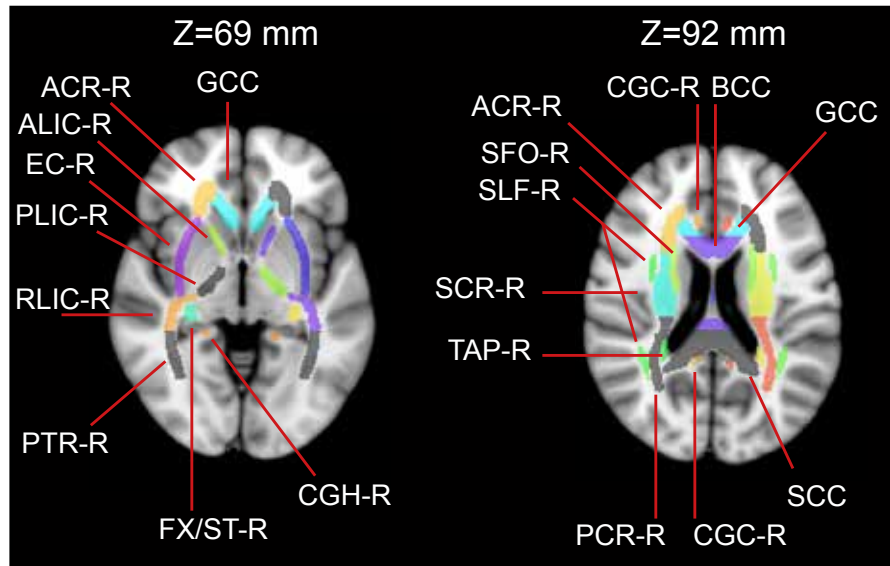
Two axial views, at $Z = 69$ mm and $Z = 92$ mm (MNI coordinates), of the WM atlas ICBM-DTI-81, showing a subset of the 50 ROIs, overlaid on the MNI152 T1-weighted standard space. Bilateral ROIs are labeled on the right ("-R") side only.
